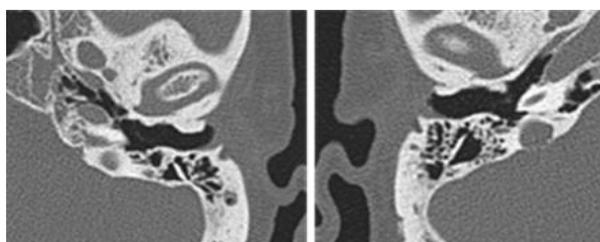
(a) Shaped axial CT scan of the right temporal showing coincidence, exostotic bone, small size in the anterior wall and deeper than the external auditory canal. (b) A left temporal axial CT scan revealed a large bony exostosis on the lateral side of the external auditory canal
